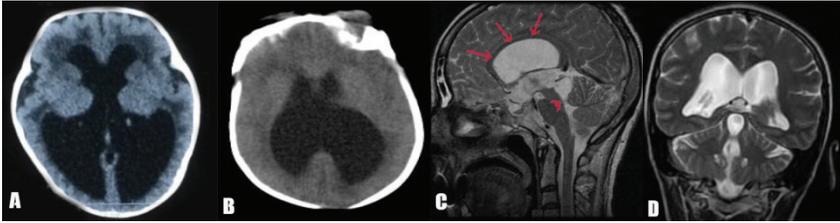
CT scan and MRI findings in Hydrocephalus.
